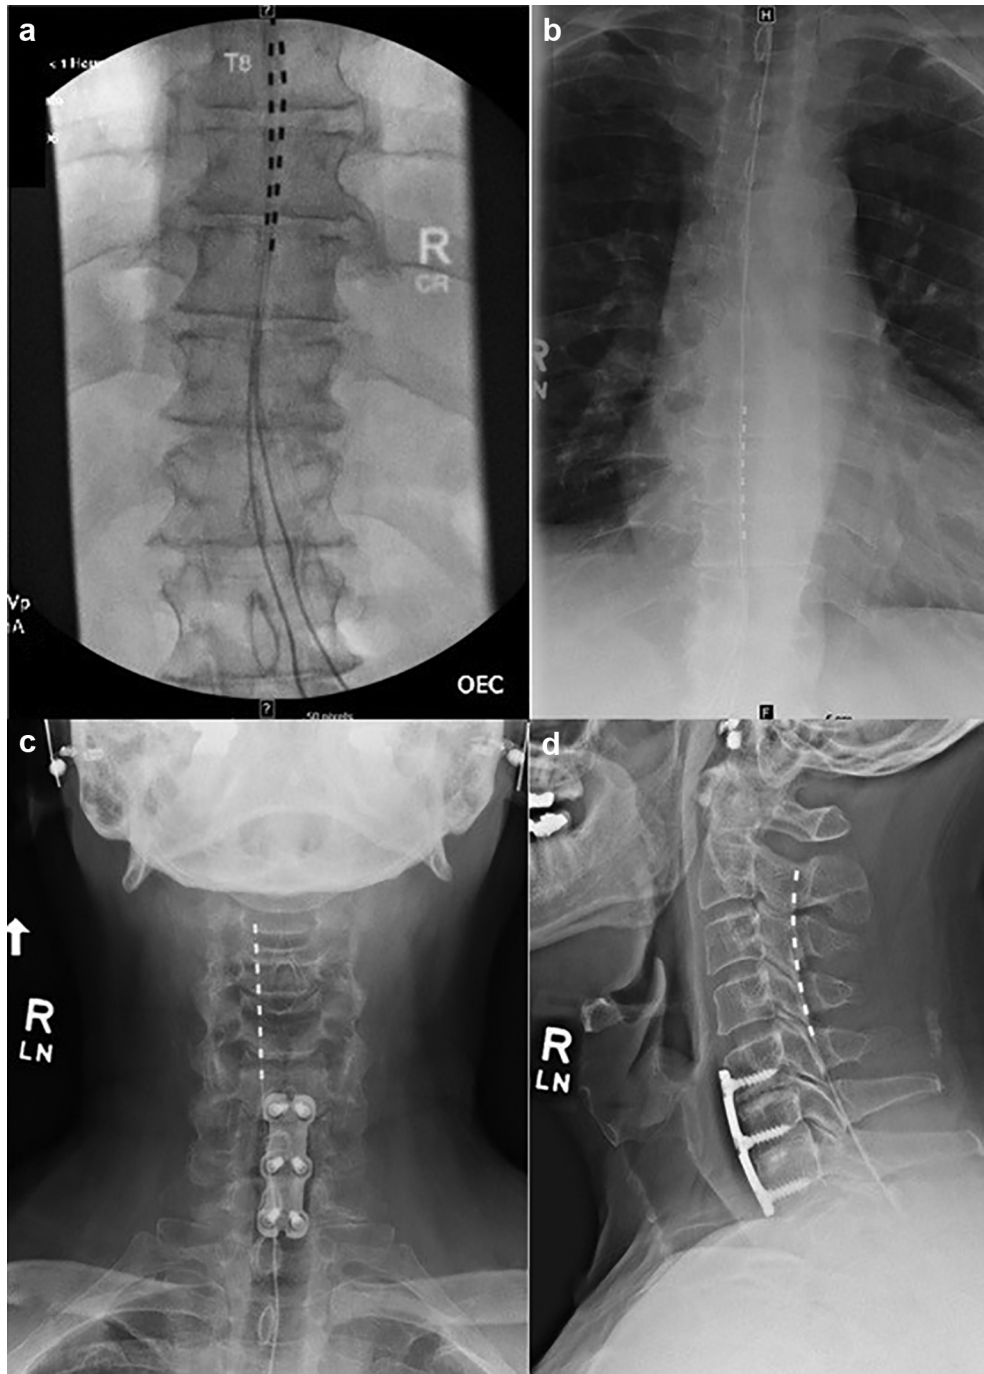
(a) Spinal cord stimulation (SCS) trial procedure. Last fluoroscopy image showing both leads near the top of T8. (b) Lead migration. Thoracic anteroposterior (AP) radiograph showing 1 lead at T8 and the other tracking cephalad. (c, d) Lead migration. Cervical spine AP and lateral radiographs showing lead migration up to C2.
